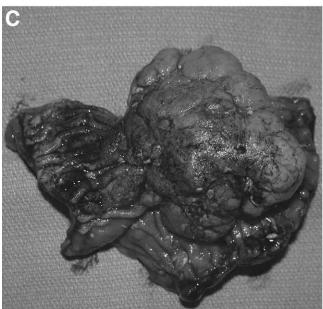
(A) Peutz–Jegher polyp lead point for intussusception. (B) Upper gastrointestinal radiographic series demonstrating Peutz–Jegher polyp within duodenum. (C) Peutz–Jegher polyp of the duodenum.
